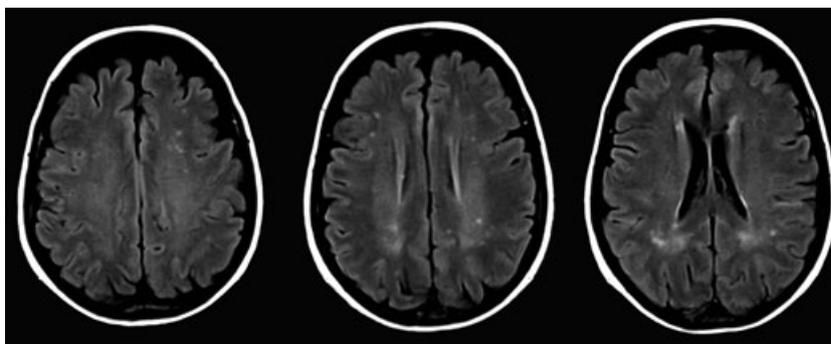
MRI T2 Flair – Tiny T2 hyperintense lesions in the periventricular and subcortical regions.
